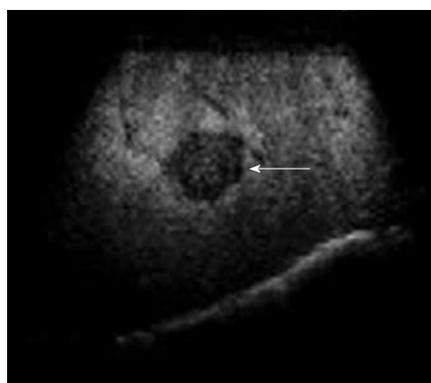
A 70-year-old man with a 2.0-cm hepatocellular carcinoma nodule located in segment 6 of the liver. Contrast-enhanced ultrasound using sonazoid shows the defect (arrow) imaging in post-vascular phase. The defect lesion can be targeted for insertion of a single needle by extending the time limitation.
